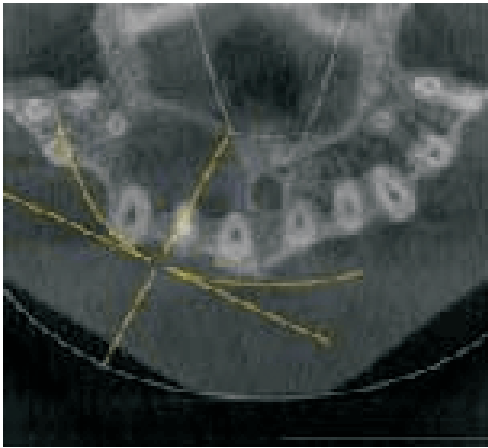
CBCT image after 6 months -occlusal view
